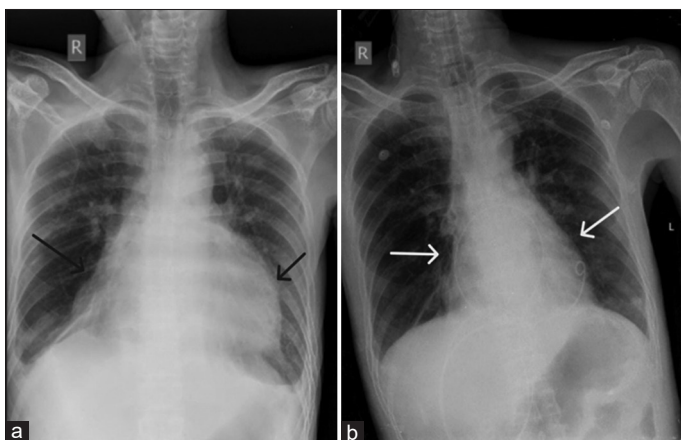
(a) Initial chest X-ray (CXR) showing blunting of bilateral costophrenic angles (left > right), suggestive of pleural effusion and “money bag” appearance of the heart suggesting pericardial effusion (black arrows). Repeat CXR post-pigtail showing resolution of the pericardial effusion (white arrows)
